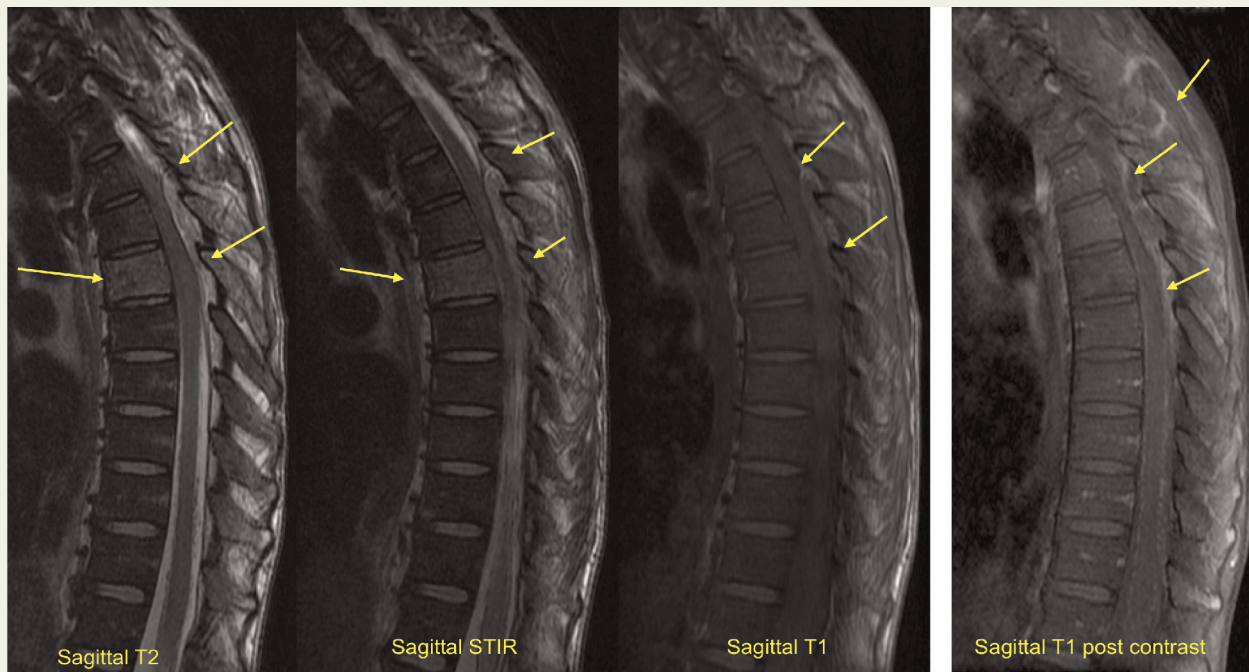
MRI images showing epidural collection with pressure effect on mid-thoracic cord and marrow changes on T6 vertebrae.
